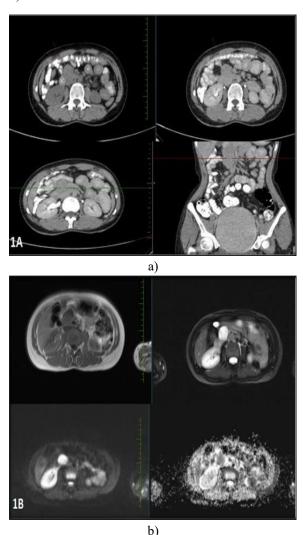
a) CT image displaying a heterogeneous, well-defined lesion (31 x 29 x 26 mm) in the pancreatic head, and b) MRI showing a well-defined, exophytic lesion with smooth margins in the pancreatic head, hypointense on T1WI and hyperintense on T2WI.
